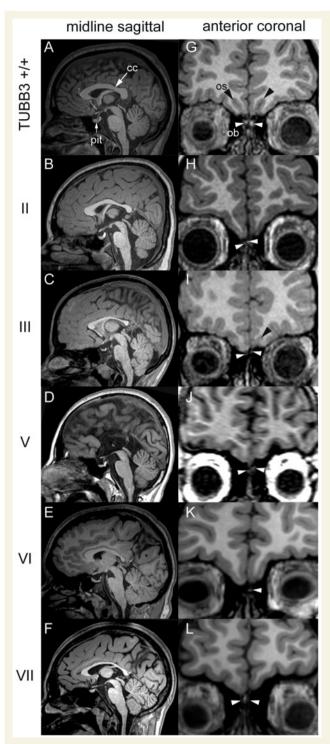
Midline sagittally acquired (A–F) and coronal reformations (G–L) of volumetric T_1 -weighted magnetic resonance images demonstrate abnormalities of the corpus callosum, pituitary gland, olfactory sulci and olfactory bulbs in individuals with the TUBB3 E410K substitution. (A) Corpus callosum (cc) and pituitary gland (pit) in a control individual. (B–F) The TUBB3 E410K substitution produces variable corpus callosum abnormalities, including diffuse thinning (C and F), hypoplasia of the posterior body (B), rostral dysgenesis with posterior hypoplasia (E) and complete agenesis (D). The pituitary gland appears small in all subjects, as can be seen in Kallmann syndrome. (G) Olfactory sulci (black arrowhead, os) and olfactory bulbs (white
